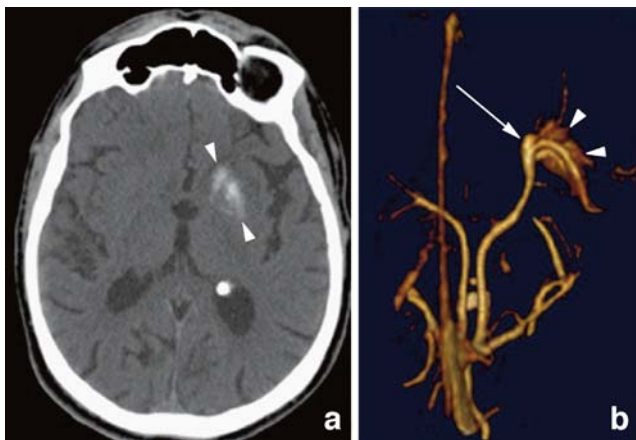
An 83 year-old man presenting a right middle cerebral artery (MCA) infarction. a Non-injected CT showing dystrophic calcifications in the left basal ganglia (*arrowheads*). b 3D reconstruction of CTA acquisition (Vitrea workstation, Vital Images, Minnetonkam Minn.) showing a medium-sized DVA draining the left basal ganglia and internal capsule into the internal cerebral vein. Calcifications are visible between the venules forming the caput medusa (*arrowheads*). Note the ampullar dilatation (*arrow*) of the proximal portion of the DVA when compared to the more distal portion of the collecting vein. The left sylvian cistern looks larger than the right one, although this was due to an asymmetric acquisition rather than atrophy in this case
